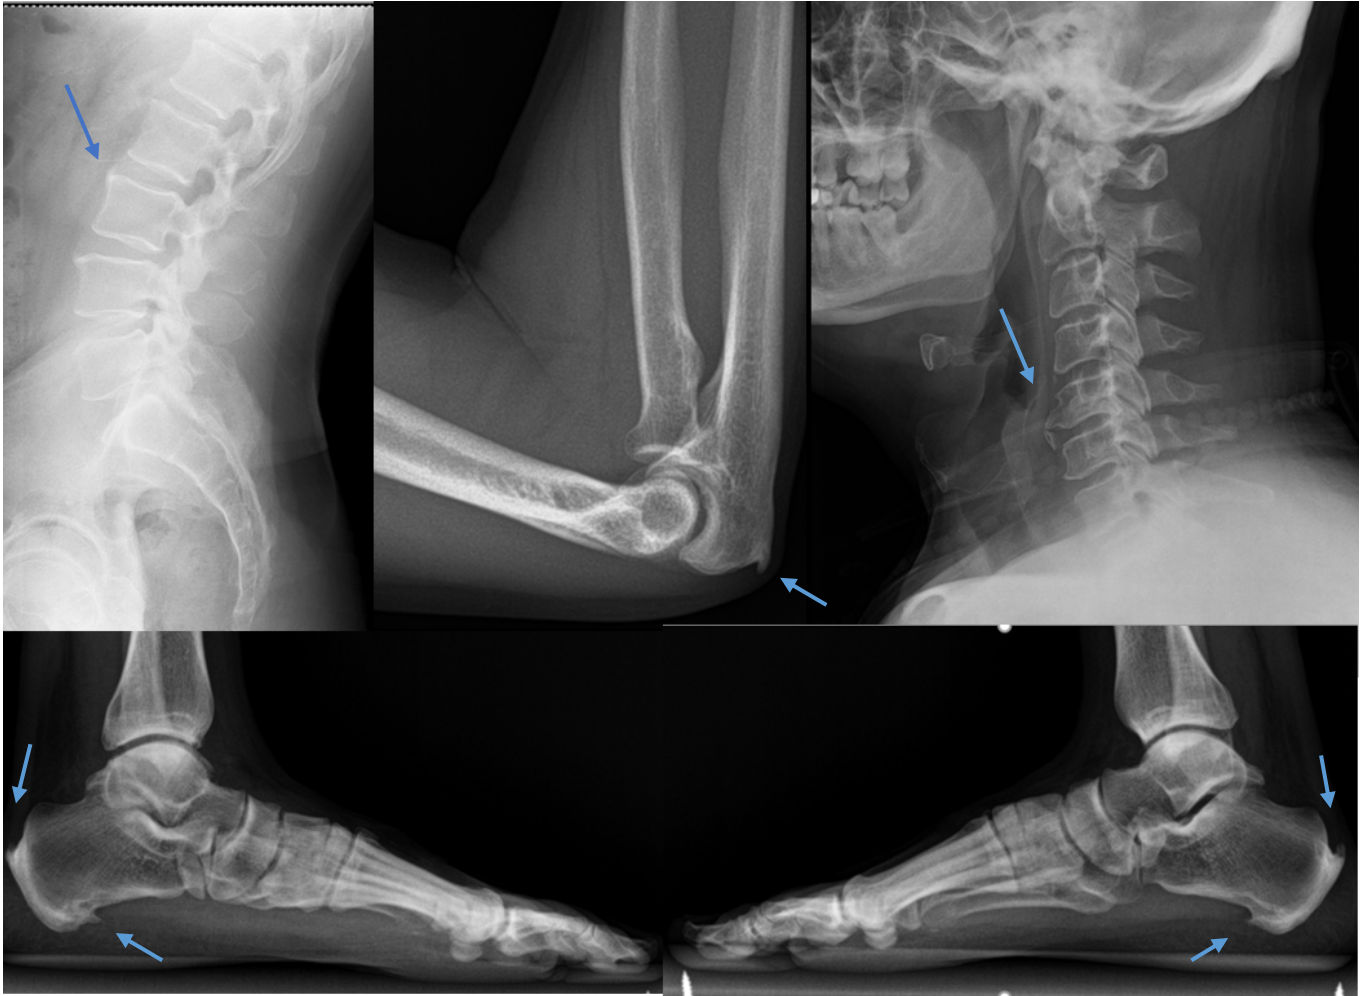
Radiographic images of different enthesis sites of a 50-year-old male patient with delayed diagnosis of axial spondyloarthritis.
